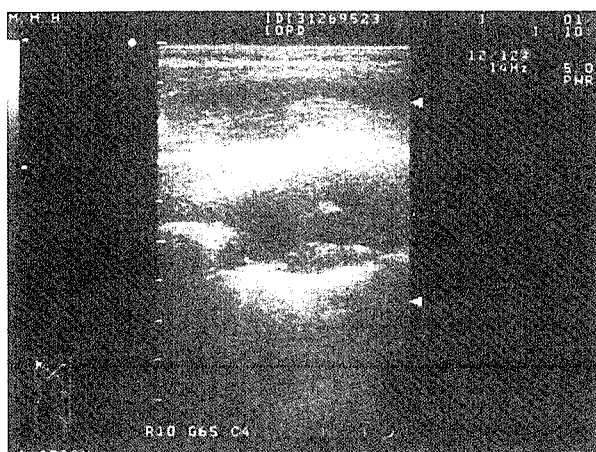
Chest ultrasonography reveals a hypoechoic mass on the lateral aspect of the right chest wall.
